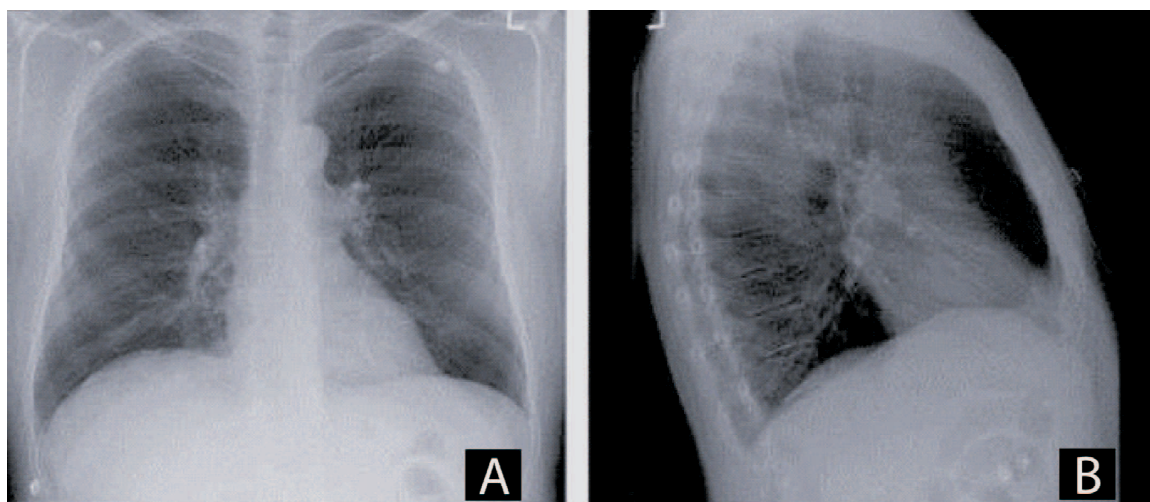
Chest X-Ray of a 63 year old male COPD Stage III subject (A) P-A view (B) Lateral View. Adapted from Parraga et. al (2007).³
